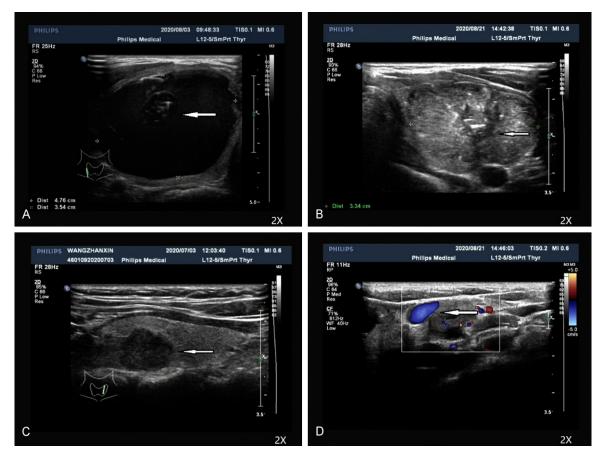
Analysis of different ultrasound features of thyroid carcinoma in the different stages. Thyroid cysts (benign lesions) had homogeneous internal echoes, unsmooth margins, and regular shapes (A). The advanced thyroid carcinoma had severe nodular calcification and heterogeneous internal echoes (B). The advanced thyroid carcinoma with lymph node metastasis had hypoechoic masses, regular shape, heterogeneous internal echoes, unsmooth margins, scattered edges (C), and rich blood flow (D).
